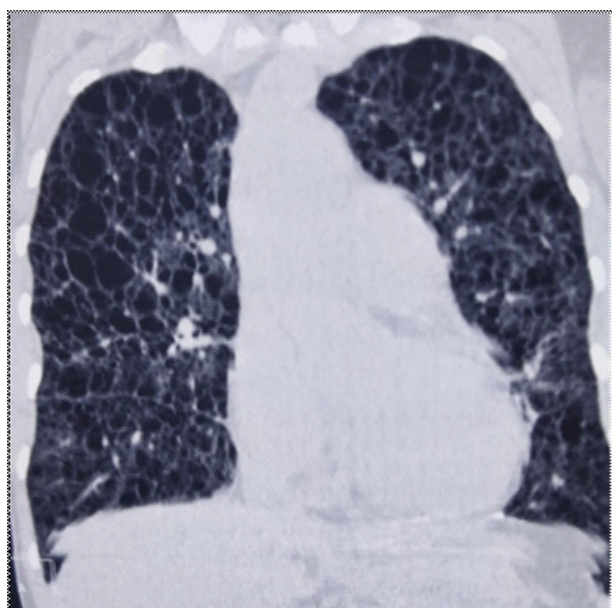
Coronal Section of HRCT Thorax showing multiple cysts and interseptal thickening
